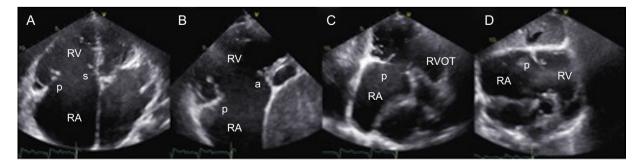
Transthoracic imaging views for tricuspid valve evaluation. A: on-axis 4-chamber view. B: parasternal short axis view. C: on-axis 2-chamber view with the RV in the apex of the sector. D: subcostal view. a, anterior leaflet; p, posterior leaflet; s, septal leaflet; RA, right atrium; RV, right ventricle; RVOT, right ventricular outflow tract.
